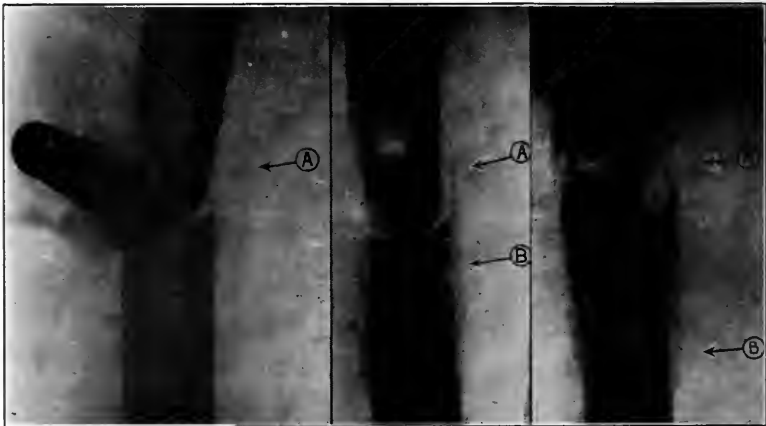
X-ray: Formation of an end sequestrum, the result of sepsis in the medulla destroying the blood supply to the end of the bone. The soft tissues are perfectly drained but the medullary cavity had poor drainage. *A*, follows the course of sequestrum over five months; *A* indicates the sequestrum; the first picture shows a drainage tube of good size and situation but demonstrates the fact that too close apposition of the fractured ends obstructs medullary drainage. *B*, indicates circumferential callus. Note cloacæ and poor honeycombed callus; note the progressive rarefaction of the entire bone, due to disuse
